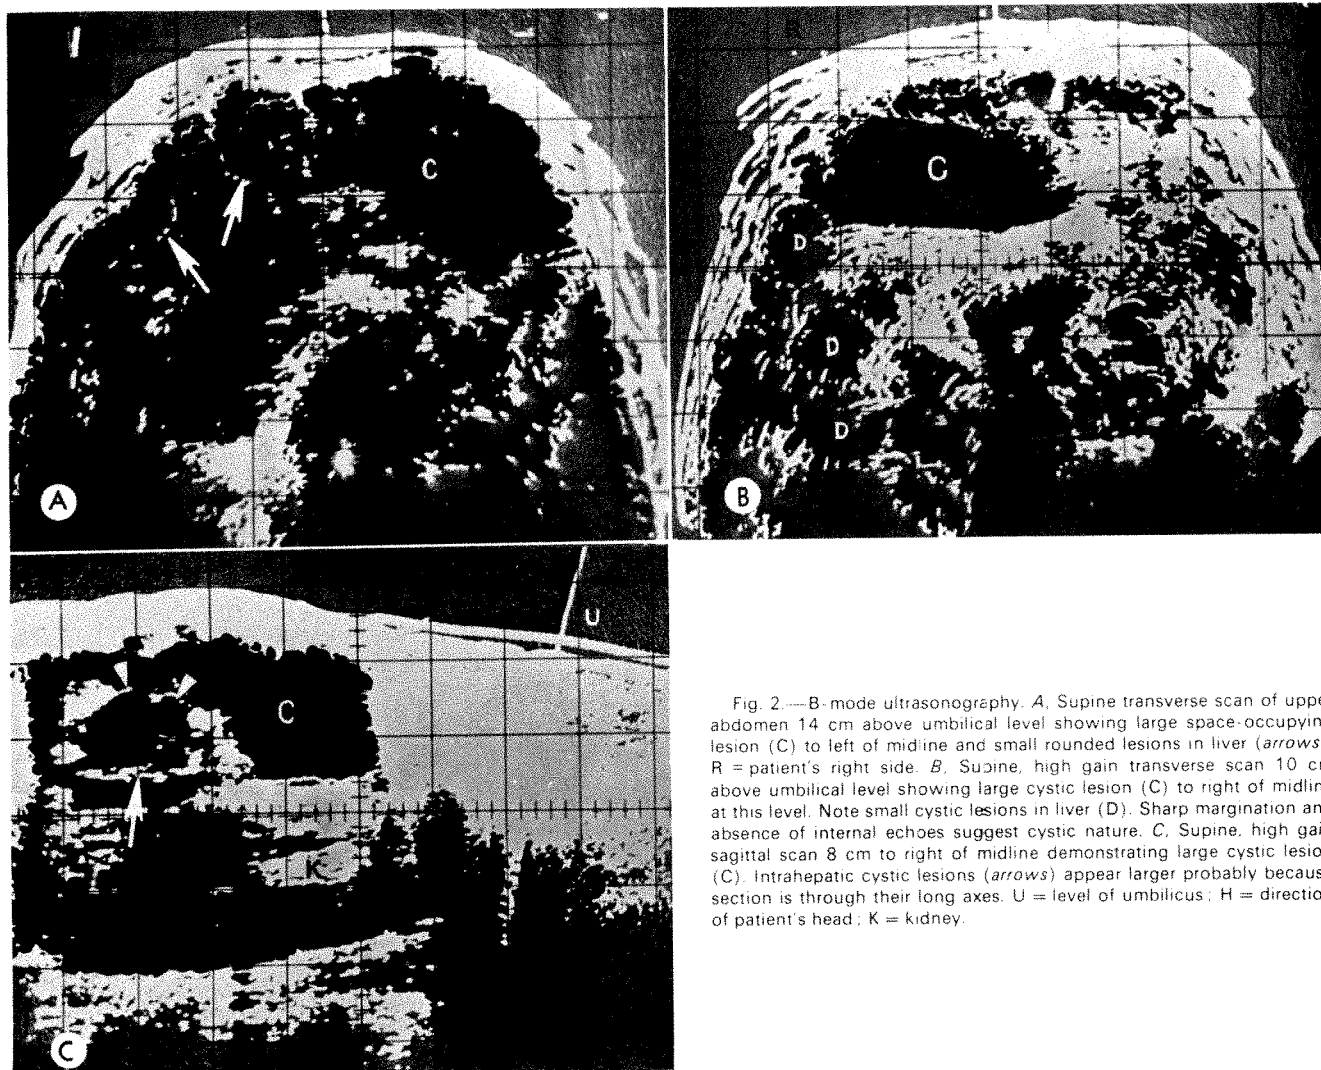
B-mode ultrasonography. *A*, Supine transverse scan of upper abdomen 14 cm above umbilical level showing large space-occupying lesion (C) to left of midline and small rounded lesions in liver (arrows). R = patient's right side. *B*, Supine, high gain transverse scan 10 cm above umbilical level showing large cystic lesion (C) to right of midline at this level. Note small cystic lesions in liver (D). Sharp margination and absence of internal echoes suggest cystic nature. *C*, Supine, high gain sagittal scan 8 cm to right of midline demonstrating large cystic lesion (C). Intrahepatic cystic lesions (arrows) appear larger probably because section is through their long axes. U = level of umbilicus; H = direction of patient's head; K = kidney.
